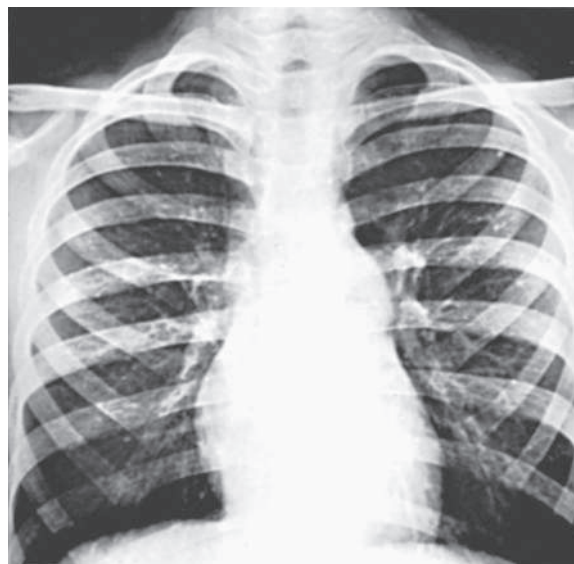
Radiograph of patient with valvular pulmonary stenosis and normal aortic root. The heart size is within normal limits, but poststenotic dilation of the pulmonary artery is present.
